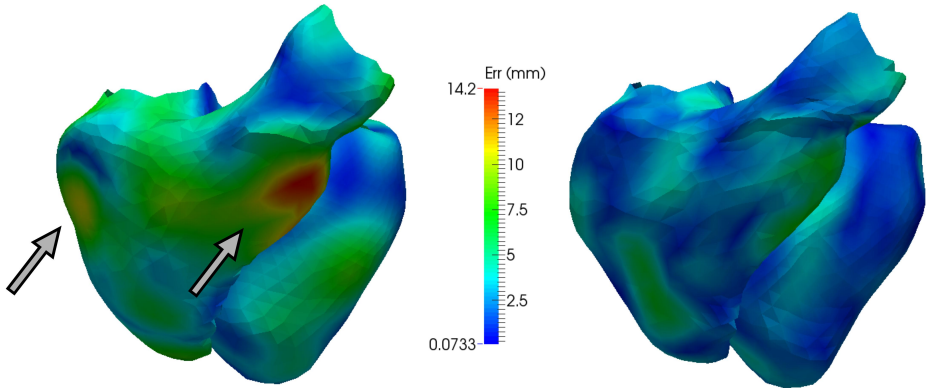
Color-coded example of the over-constrained generalization ability of the MR model (left), compared to the combined MR-CT model (right). The arrows indicate two of the areas with highest error.
